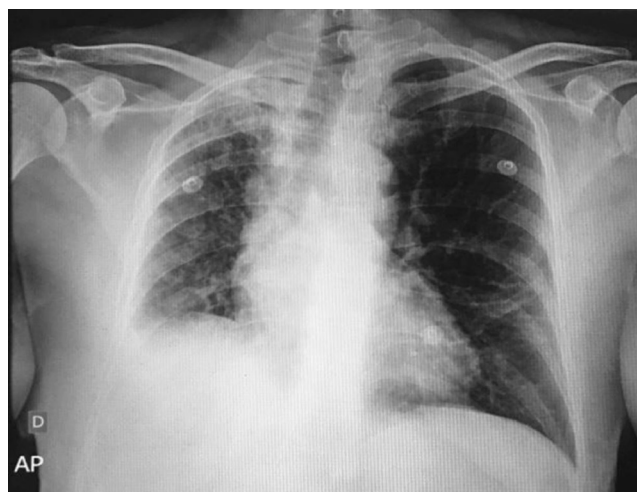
Chest X-ray showing right lung volume reduction.
